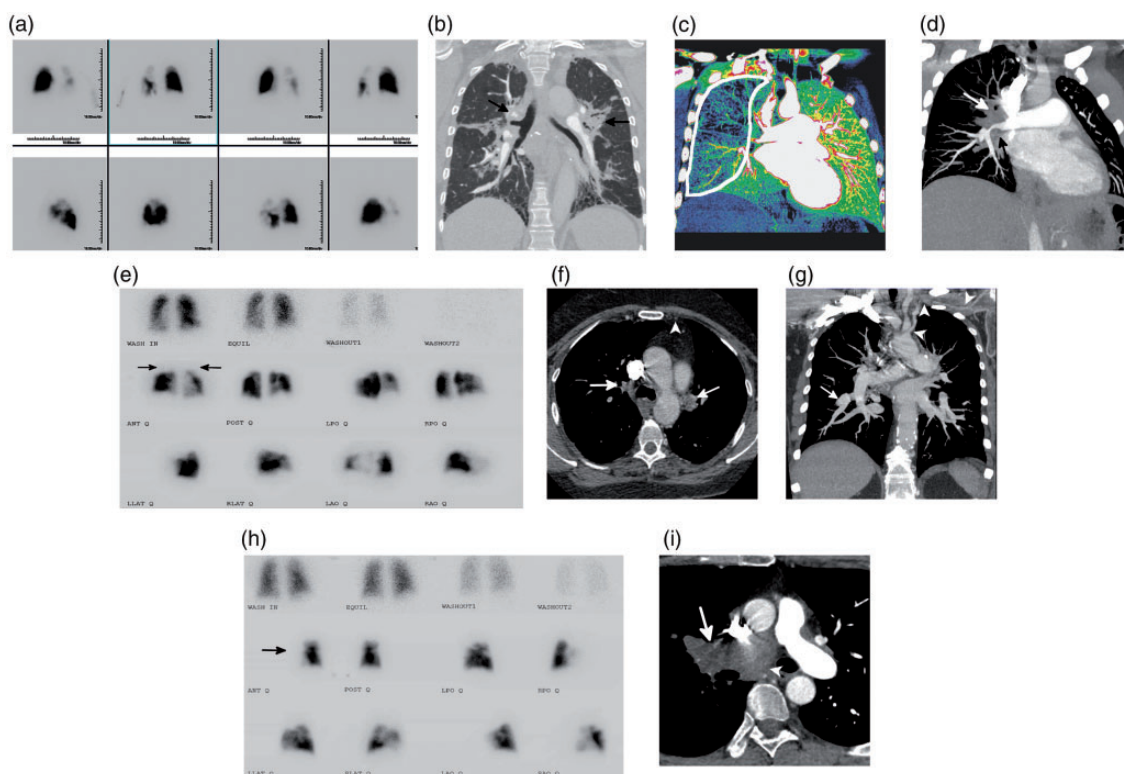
Imaging examples of CTEPH mimics. (a) Planar V/Q scan with multiple perfusion defects on the left greater than the right; ventilation was normal. (b) Coronal image from a CTPA using a lung window algorithm showing compression and narrowing of the central vasculature due to conglomerate hilar soft tissue (black arrows) with associated perihilar fibrosis. A biopsy identified non-caseating granulomas consistent with sarcoid. (c) Left posterior oblique image from a dual-energy CTPA with significant decreased perfusion to the right lung (white outline). (d) Corresponding left posterior oblique maximum intensity projection image from the CTPA shows confluent right hilar soft tissue occluding the right upper lobe PA and severely narrowing the interlobar PA (white arrow). The right superior pulmonary vein is also occluded (black arrow). A biopsy identified paucicellular eosinophilic collagen, confirming the diagnosis of fibrosing mediastinitis. (e) Planar V/Q scan with bilateral upper lobe mismatches (black arrows) as well as a few additional subsegmental defects. (f) Axial CT image shows the occlusions of the upper lobe pulmonary arteries (white arrows). In addition, the left internal mammary artery is occluded (white arrowhead). (g) Coronal maximum intensity projection image with areas of branch pulmonary artery narrowing with distal aneurysmal dilation (white arrow). The left subclavian and axillary artery are diffusely narrowed and irregular with circumferential soft tissue thickening (white arrowheads). The constellation of findings is suggestive of a large-vessel vasculitis. (h) Planar V/Q scan with absence of the right lung on perfusion with normal ventilation (black arrow). (i) Axial image from a CTPA showing a large soft tissue mass filling and expanding the right pulmonary artery (white arrow) and extending into the mediastinum (white arrowhead) highly suggestive of a pulmonary artery sarcoma, which was confirmed after biopsy. Source: Image supplied by the authors.
